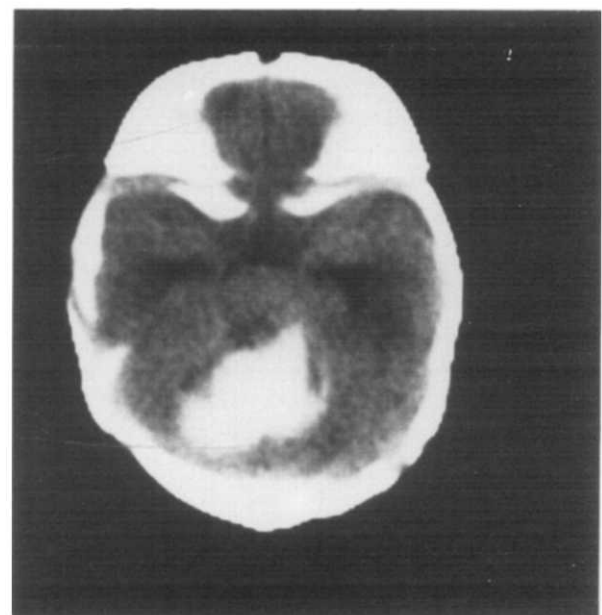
Unenhanced CT of a 36-hour-old term infant, demonstrating a high density lesion, interpreted as intraparenchymal cerebellar hemorrhage because of its subtentorial location, posterior to the fourth ventricle with evidence of neural tissue surrounding the hemorrhage.
